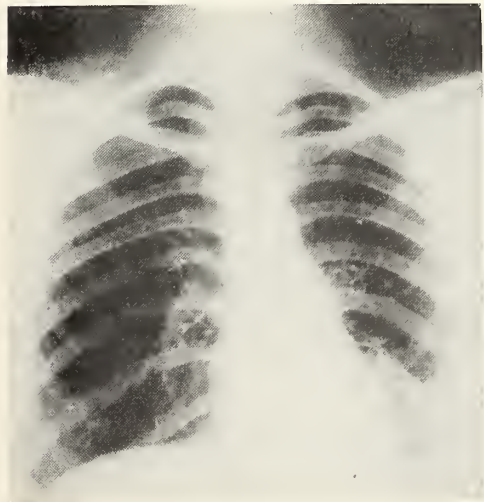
(Case No. 3) (a and b). X-ray appearance of lungs before and after iodized oil injection showing bilateral bronchiectasis and emphysema. (c and d). Appearance following bilateral resection of involved area.
